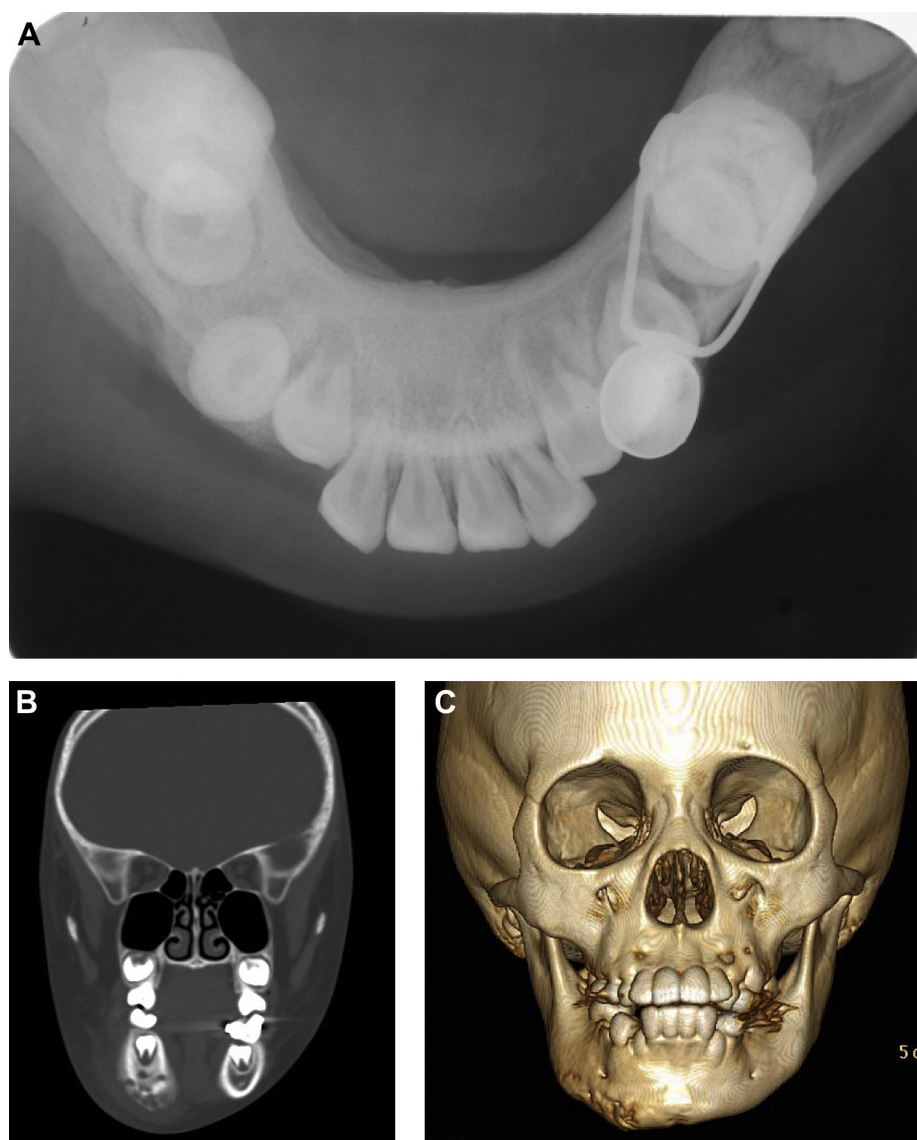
(A) An occlusal radiograph of the mandible showed the enhancement in peripheral subperiosteal bone on the right buccal and lingual sides. (B) Coronal section computed tomography of the bulging area demonstrated severe enhancement over the periosteum. (C) Coronal section three-dimensional computed tomography of the bulging area showed an additional irregular region of cortical bone extending from the parasymphysis to the right retromolar area.
